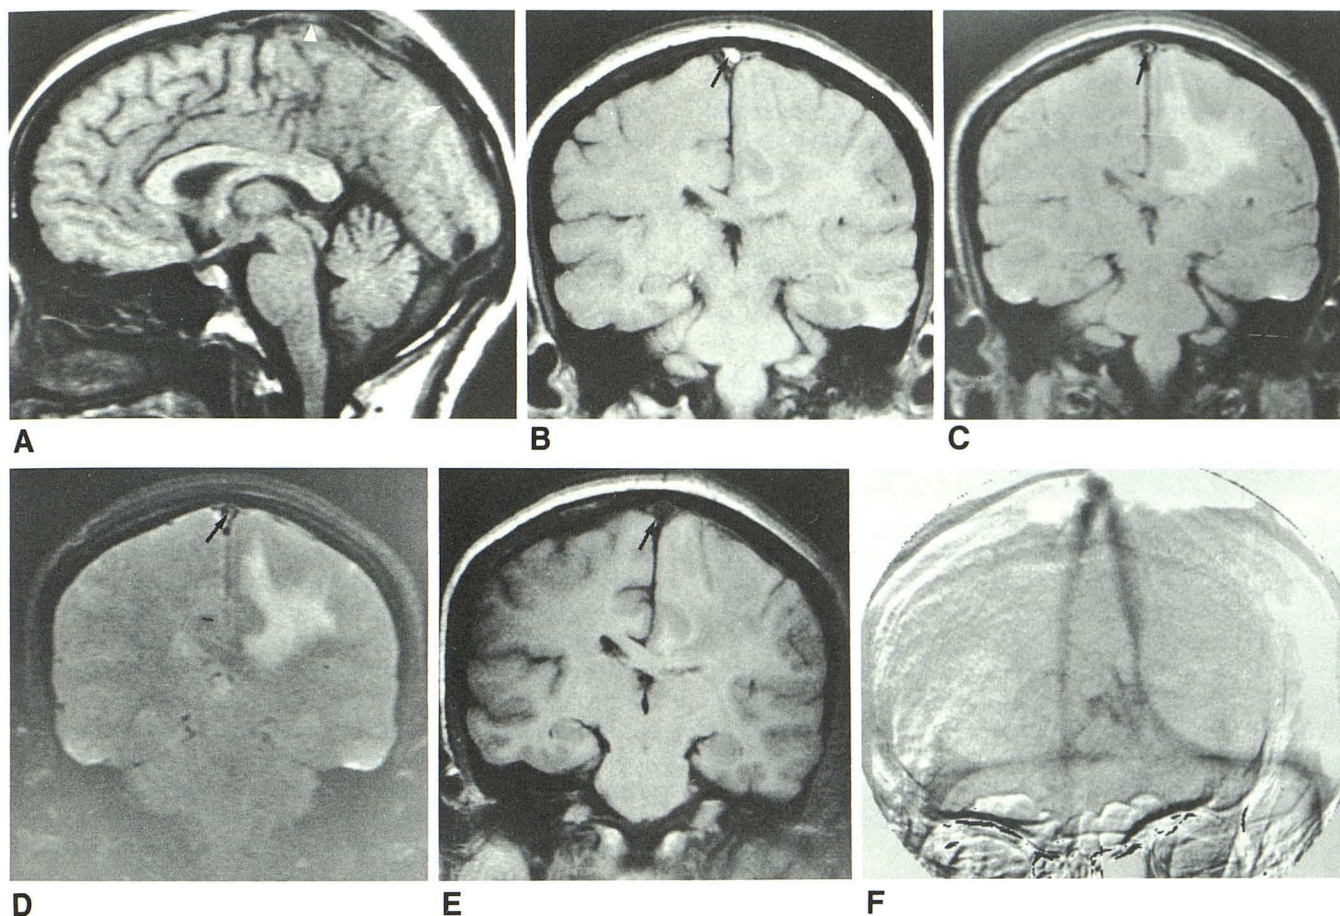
Case 2: 37-year-old woman with breast carcinoma and large skull metastasis, presenting with headache. A, T1-weighted sagittal image, 600/20, shows patent superior sagittal sinus posteriorly (arrow), with possible signal in its mid course (arrowhead), as in Fig. 1A.
